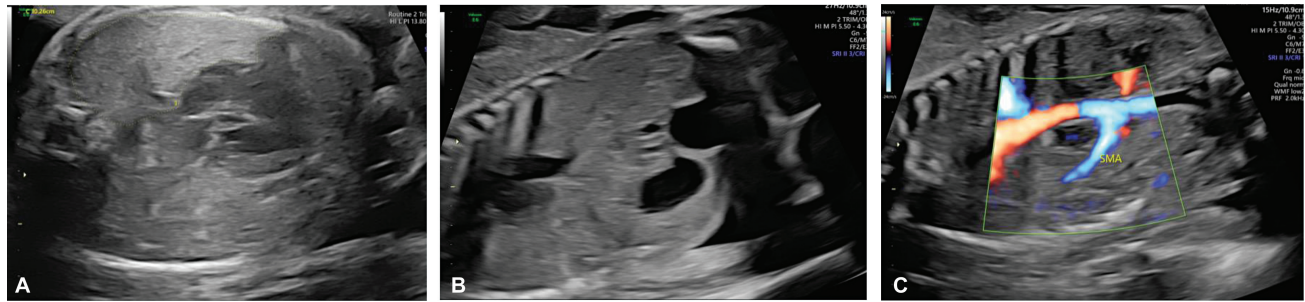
(A) Axial section of thorax showing mediastinal shift. (B) Anterior coronal sonogram showing the stomach in contact with the bladder. (C) The upturned superior mesenteric artery sign.
